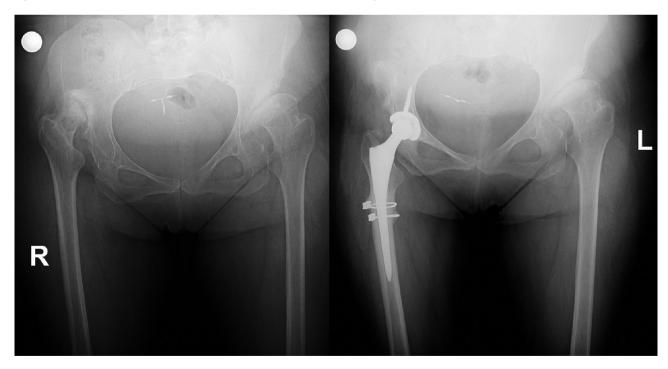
Preoperative and Follow-up Anteroposterior Pelvic Radiographs of a Patient with a Proximal Porous-Coated Tapered Stem
